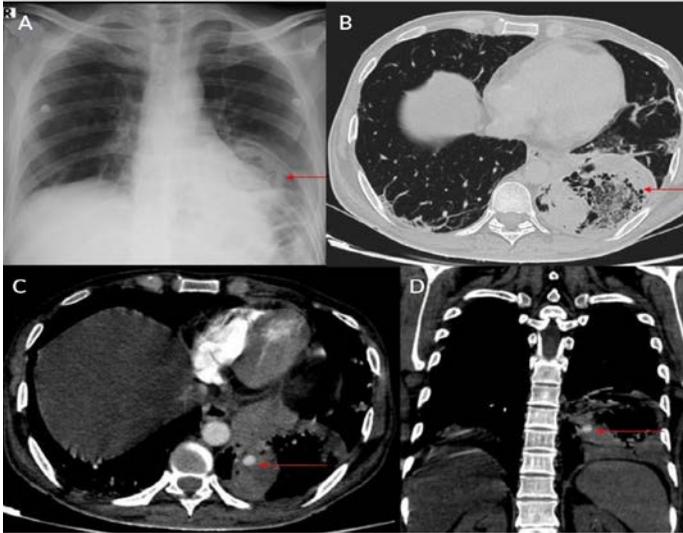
Coil embolization. (A) Chest X-ray posteroanterior view showing cavitation with surrounding changes of consolidation involving the left lower zone. (B) High-resolution computed tomography chest axial image showing cavitation with internal debris and surrounding areas of consolidation involving the left lower lobe. (C) and (D) Axial and coronal images in the mediastinal window showing an aneurysm involving the posterior basal segmental branch of the left descending pulmonary artery.
